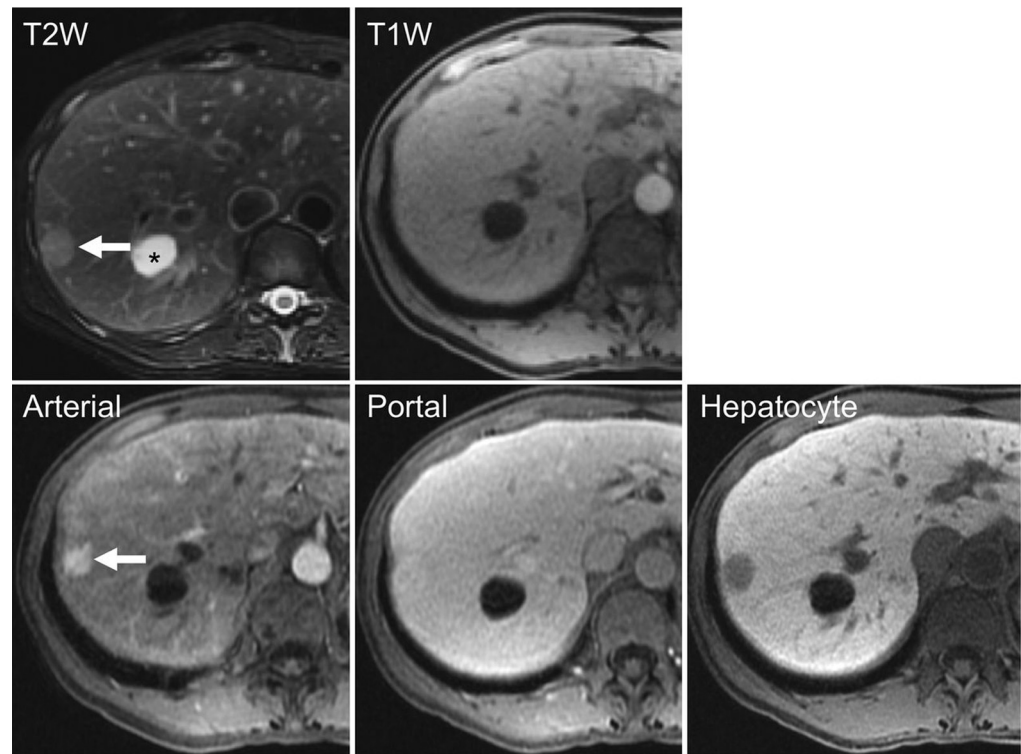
Hepatic adenoma (arrow) in the right lobe of the liver. The adenoma is hyperintense to liver on the T2-weighted image and isointense on the T1-weighted image. It is hyperenhancing in the arterial phase but nearly isointense in the portal venous phase and does not take up Eovist in the hepatocyte phase. An adjacent simple cyst is marked on the T2-weighted image (asterisk). T1W, T1-weighted; T2W, T2-weighted.
